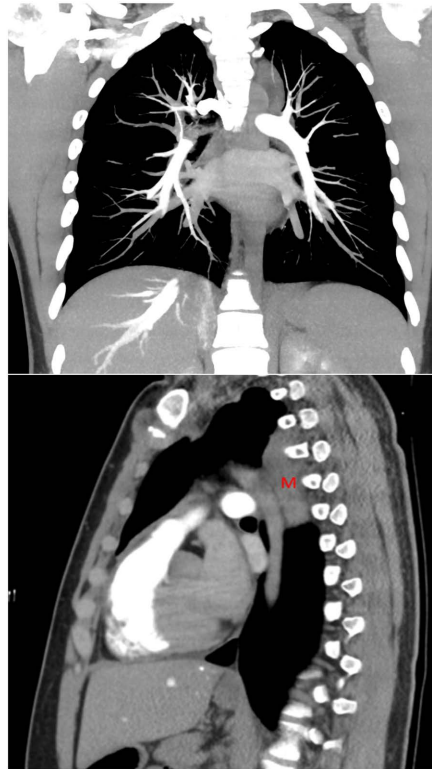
Pulmonary Angiography CT (M = Mass).
